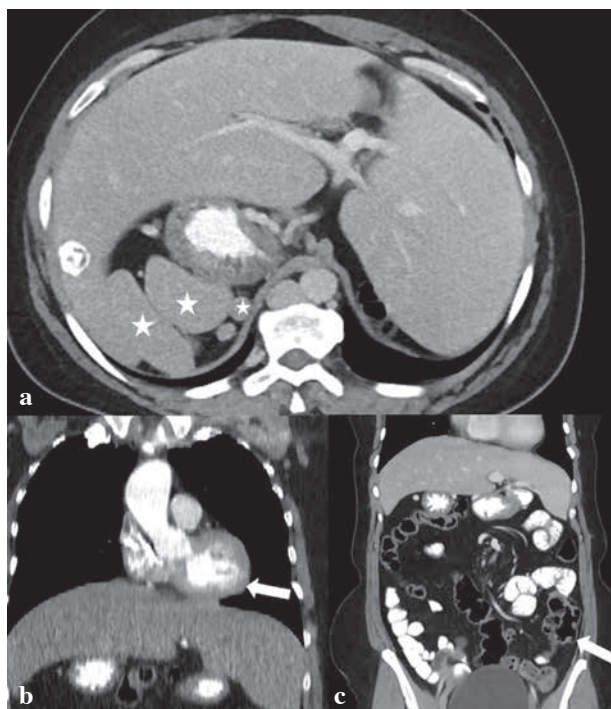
The abdominal CT examination showed partial situs inversus and polysplenia. (a) The liver was located on the left, the spleen on the right. (b) The heart was in its normal position (arrow). (c) The cecum was observed to be in the lower left quadrant (arrow). Multiple spleens located in the upper right quadrant were observed and were consistent with polysplenia (1a, asteriks).
